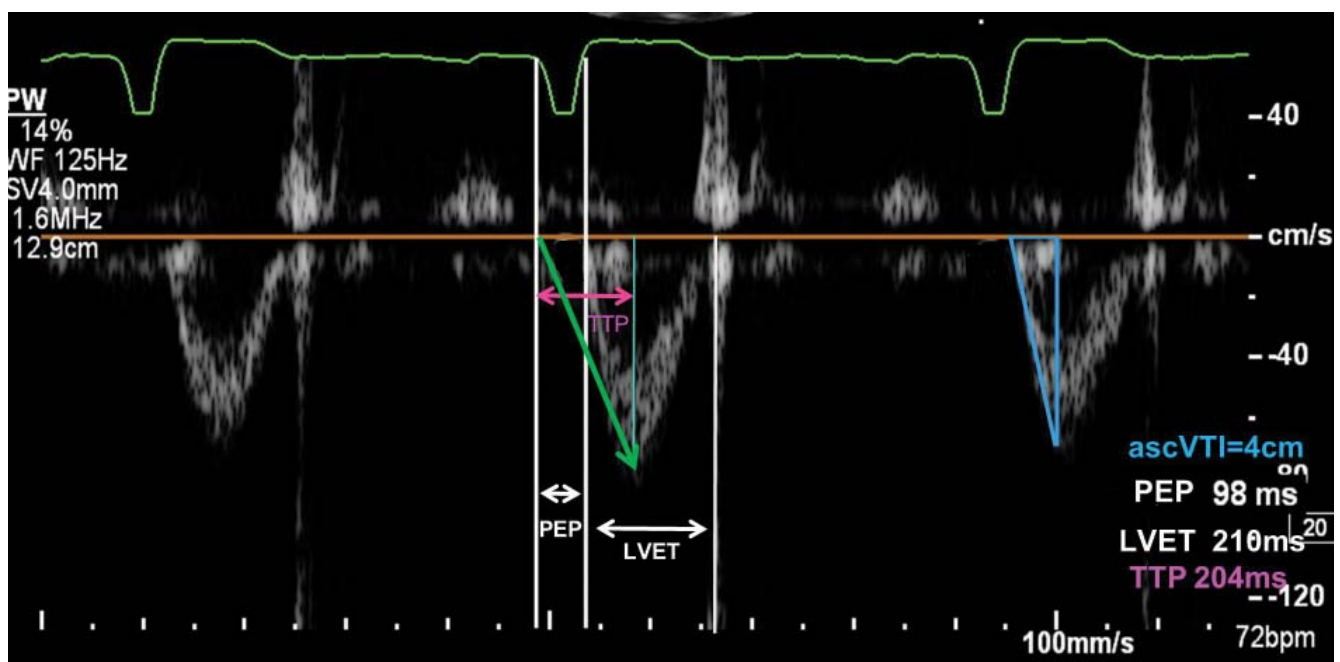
Pulsed wave Doppler (PW) envelope in left ventricular ejection fraction. showing systolic times and acceleration to peak systolic LVOT velocity. Measurements are averaged over 3 cycles. PEP preejection time, measured from beginning of QRS to start of ejection; LVET ejection time, measured from beginning to end of the PW envelope; TTP time to peak systolic velocity, Green arrow depicts the initial systolic acceleration.
